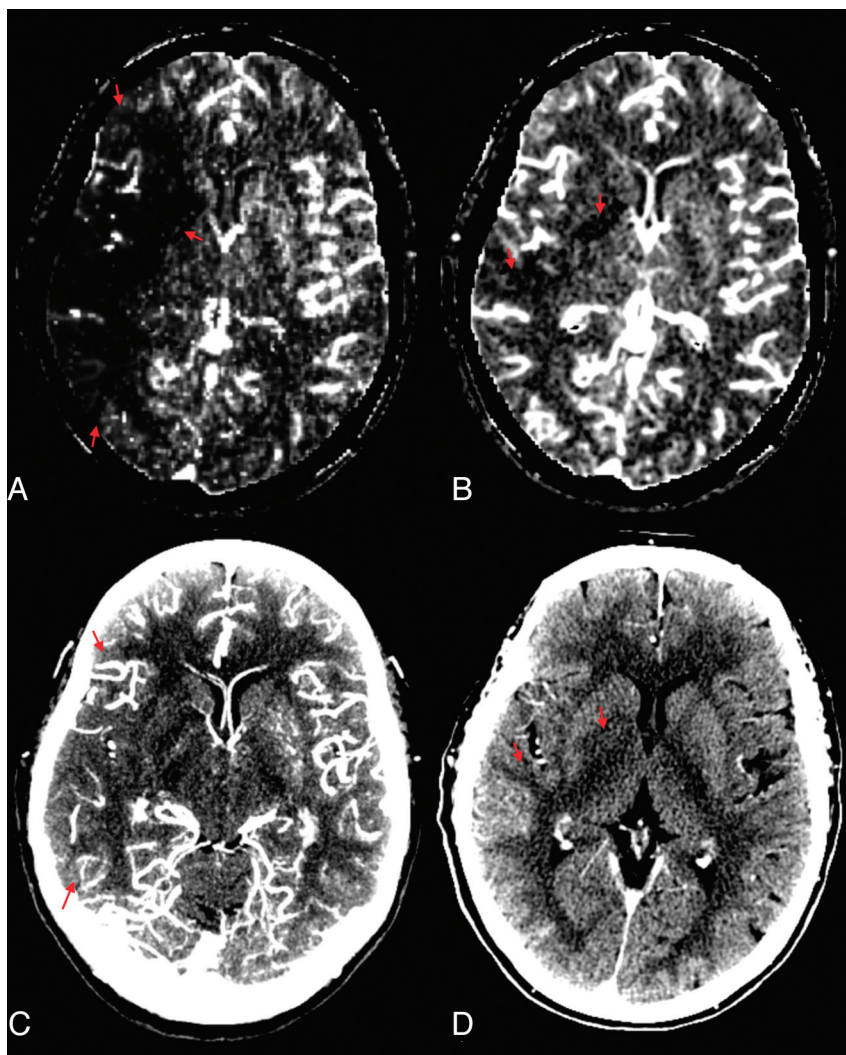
CBF (A) and CBV (B) maps. C, The hypoattenuation of CTA source image and gray-white matter differentiation loss correspond more closely with the CBF than with the CBV map. D, PCCT hypoattenuation corresponds most closely with CBV defect.
